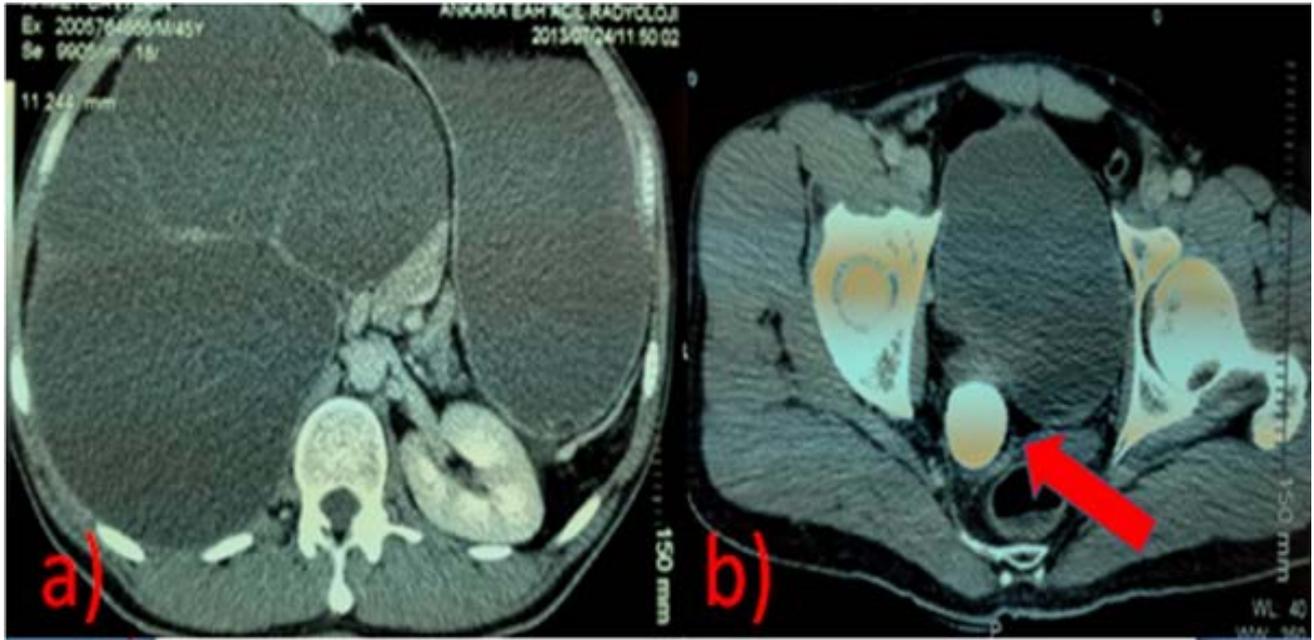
Abdominal computed tomography a) Massive gastric dilatation and duodenal obstruction due to giant hydronephrosis b) 3,5x3cm giant ureteral stone
